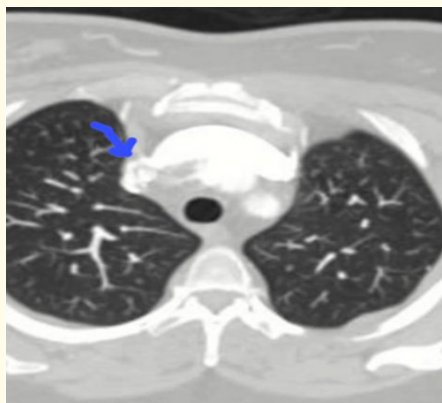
Thoracic CT angiography shows a filling defect corresponding to a thrombosis at the superior cava and right atrium level at the entrance of the superior cava.
